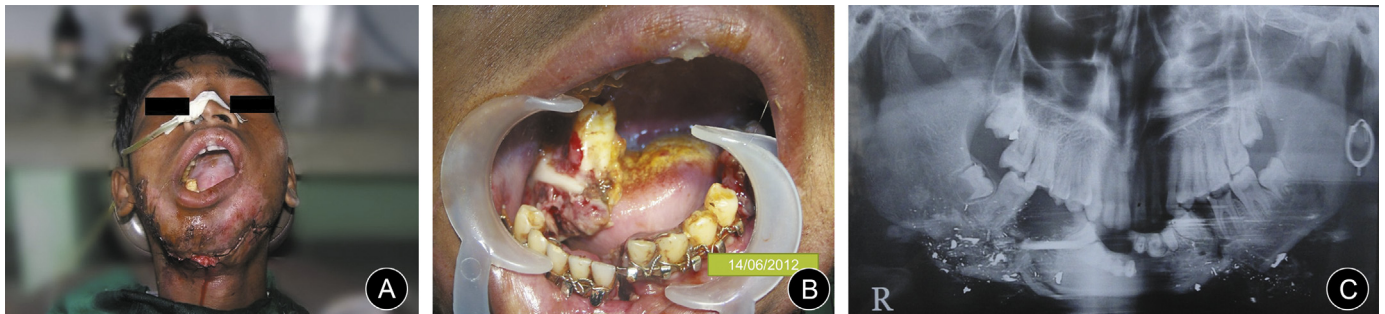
A: Preoperative photograph of the patient with lacerating injury marks in the lower part of the chin. B: Multiple fractured segments visible in mandibles on both sides. C: Preoperative orthopantomogram view showing bilateral mandibular body fracture with middle symphysis fracture. Multiple radioopaque loose bony fragments and foreign pellets are seen around right side entry and left side exit wound region.
